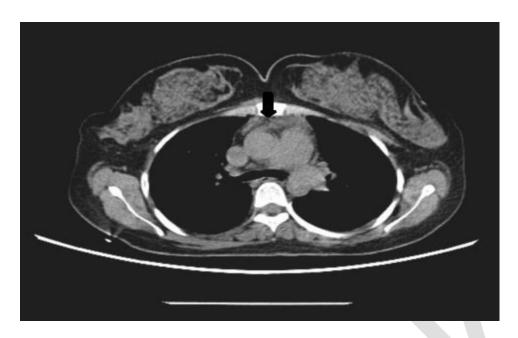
Thymic remnant causing low levels of FDG uptake was observed in reticular densities in the anterior mediastinum (black arrow)
